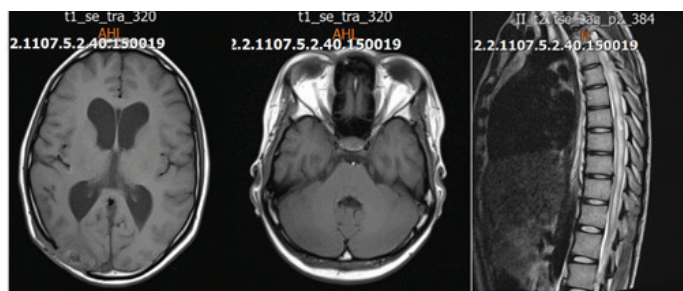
post-operative brain and cervico-thoracic MRI: Controlled MRI showed a thoracic and lumbar syringomyelia and no tuberculomas in the brain.
